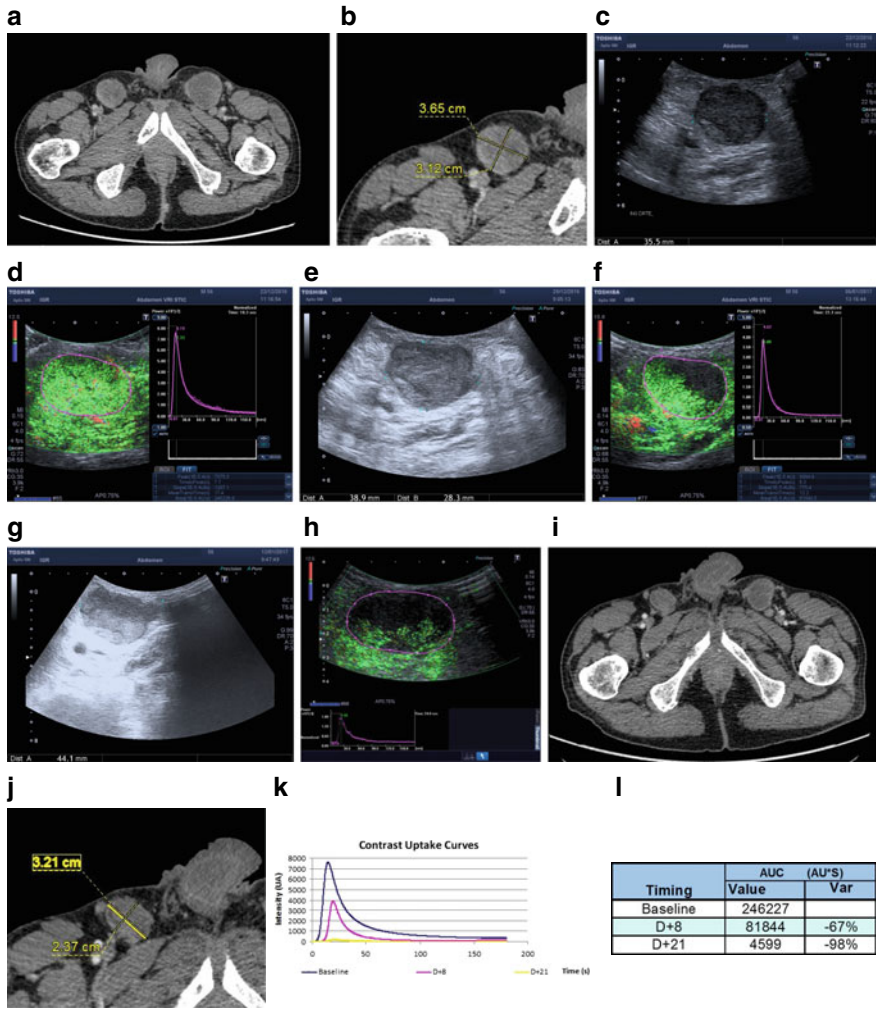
A 57 years old man with metastasis from melanoma was treated by a combination of two immunotherapies. The targeted lesion was an inguinal lymph node. At baseline, a CT-scan (a, b) and DCE-US were performed. The lesion was hypoechoic on B mode (c) and hypervascularized on VRI (vascular recognition imaging) mode (d) after injection on 4.8 ml of contrast agent. The DCE-US was performed at D8 after the start of therapy showing the same size on B mode (e) but a decrease of vascularization at the peak arterial (f). The results were confirmed on day 21 with DCE-US in B mode (g) and VRI mode (h). The CT-scan shown in (i, j) was performed after 2 months of therapy, indicating stable disease of the lymph node. The graph (k) and the table (l) confirm AUC as a suitable DCE-US biomarker that compared to baseline decreased more than 40% at day 8 and day 21
